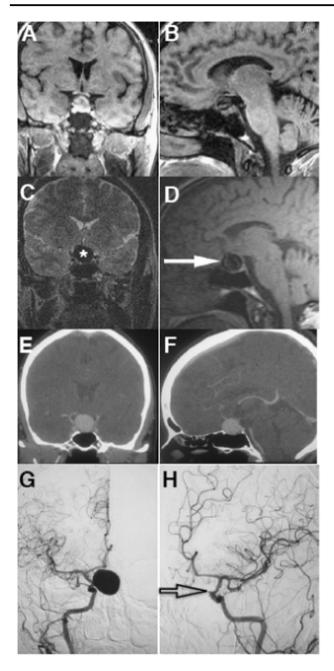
51-year-old female with a giant internal carotid aneurysm. Coronal (a) and sagittal (b) T1W MRI images demonstrate a heterogeneous round sellar lesion which measures approximately 1.7 cm × 1.4 cm × 1.3 cm. Coronal T2W (c) and sagittal T1W (d) MRI images demonstrate the black signal lesion and its contact with the right internal carotid artery (c: asterisk; d: white arrow). Post-contrast coronal e and sagittal f CT images demonstrate a saccular aneurysm which measures approximately $1.8 \text{ cm} \times 1.8 \text{ cm} \times 2.0 \text{ cm}$, with a neck width of 0.7 cm, arising from the medial-posterior aspect of the right supraclinoid segment of the internal carotid artery, with intra-sellar and supra-sellar extension. g Right side selective internal carotid artery angiogram with digital subtraction AP demonstrating a giant saccular aneurysm above the ophthalmic artery emergence measuring approximately 3 cm. h Left side selective internal carotid artery angiogram with digital subtraction oblique view depict a small mirror saccular aneurysm of approximately 0.4 cm (black arrow)
